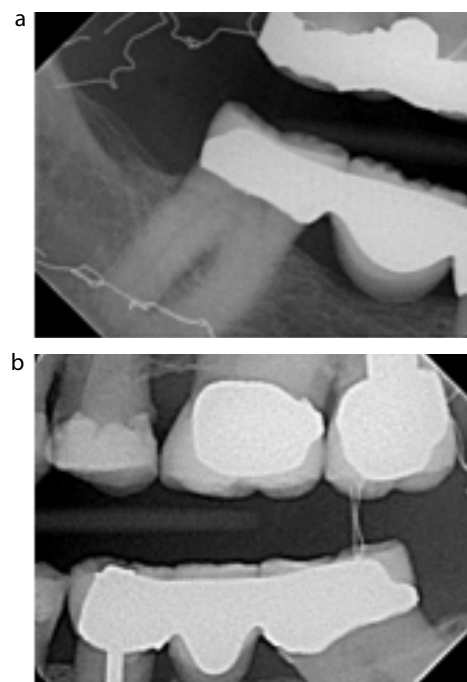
(a) Right bitewing taken 05/11. (b) Left bitewing taken 05/11.
